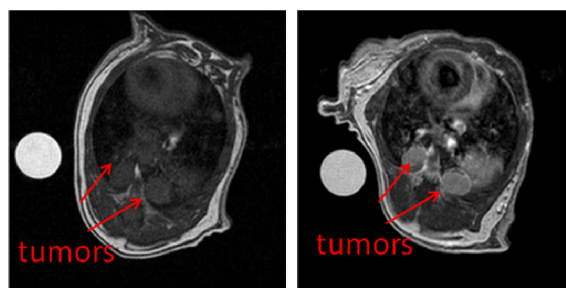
T1weighted MRI image of pulmonary metastases before (left) and after (right) contrast administration
